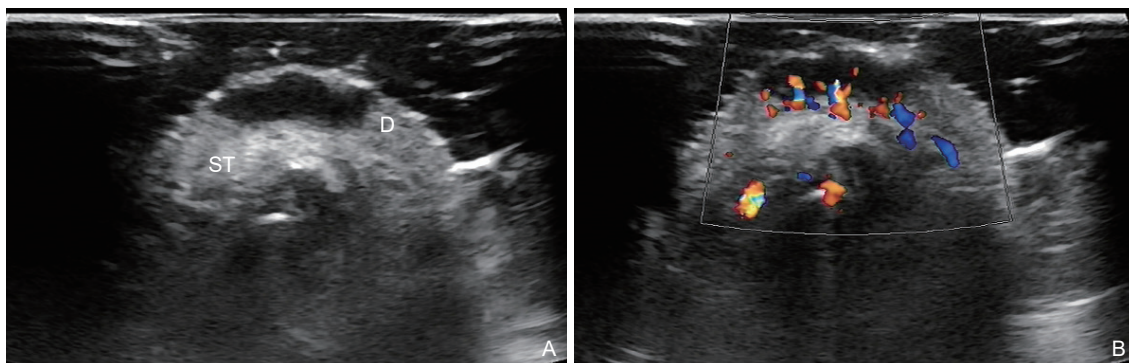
BCC in dermis (D) and subcutaneous tissue (ST). (A) sonography examination shows a 12.2×9.5mm well-defined and irregular-shaped hypoechoic mass involves the dermis and subcutaneous tissue; (B) Color Doppler sonography shows increased vascularity in the tumor.
